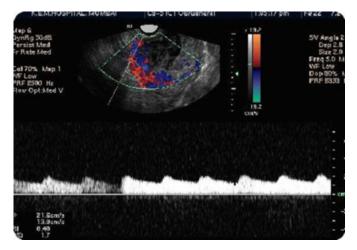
Transvaginal Ultrasound showing 10 week cervical ectopic gestation
